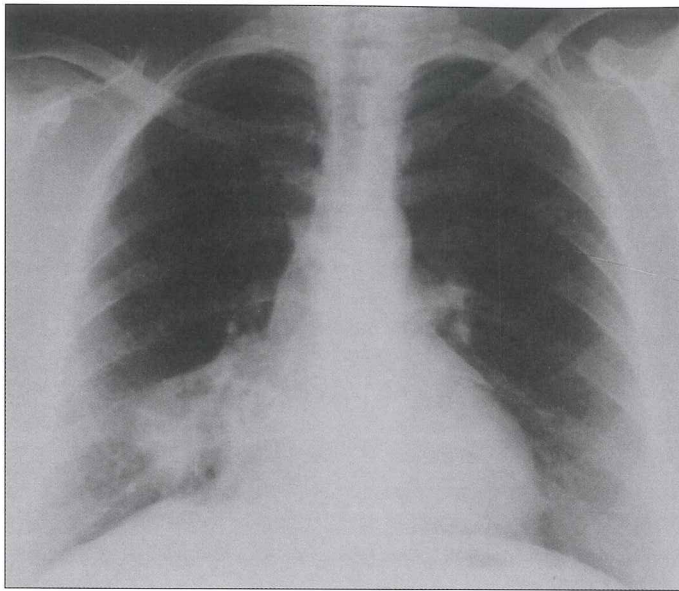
Posteroanterior chest x-ray of relatively well-demarcated opacity in the right paracardiac region
